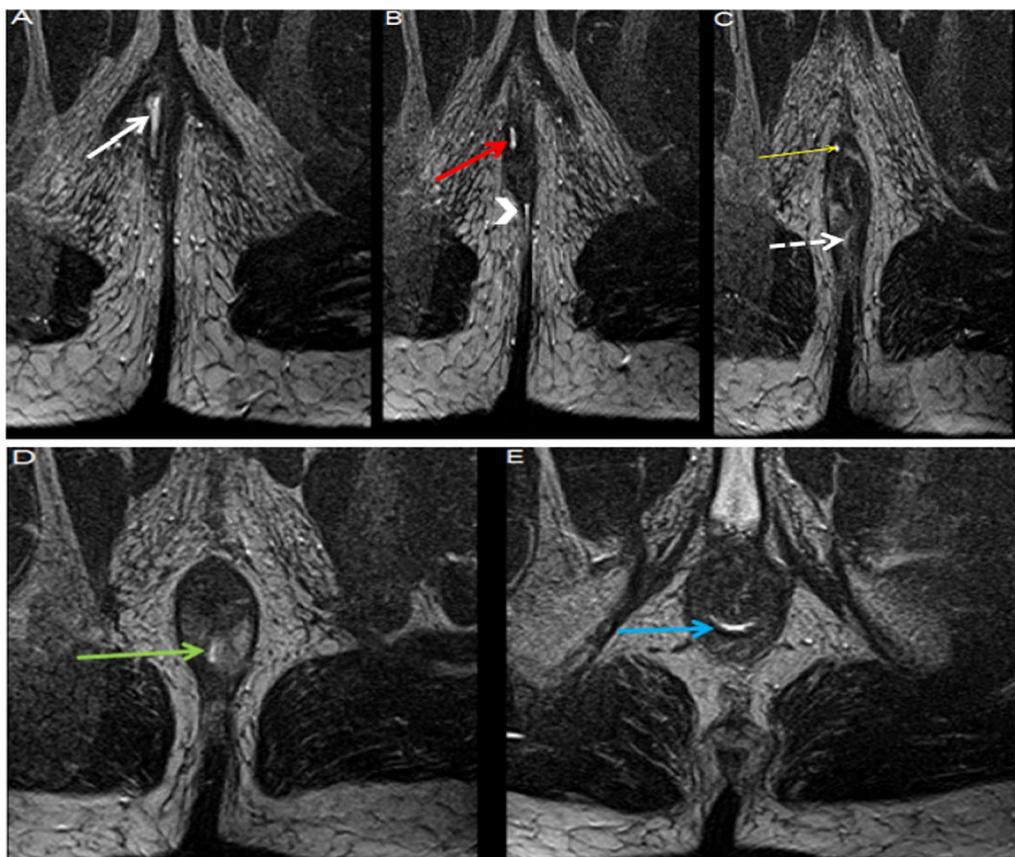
A 50-year-old male patient presented with discharging fistulous openings. MRI examination in the form of multiple pulse sequences after local injection of saline and gel revealed in axial T2 images (A–E): A External cutaneous opening of the fistulous tract at the right perianal region (white arrow). B Fistulous tract at the intersphincteric space (red arrow) with another posterior midline fistulous tract (arrowhead). C Internal mucosal opening at 11 o'clock (yellow arrow). The posterior midline tract was seen in the intersphincteric space (dashed arrow). D The internal mucosal opening of the posterior midline tract was located in the anal canal at six o'clock (green arrow). E Extended branches on both sides of the anal canal giving a horseshoe appearance (blue arrow). The final diagnosis was a right, grade II, intersphincteric fistula
